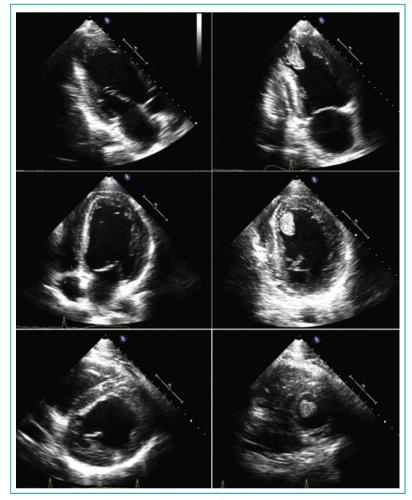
Transthoracic echocardiography reveals a large and protruding apical thrombus. The images on the left are obtained along a plane in which the thrombus does not fall. The images on the right have been optimized to view the thrombus. The thrombus resides in an inferior apical aneurysm; given the tendency of apical views to foreshorten the apex, the area of disease is less apparent on standard views. Reproduced, with permission, from Hutchison and Rudakewich [57].
